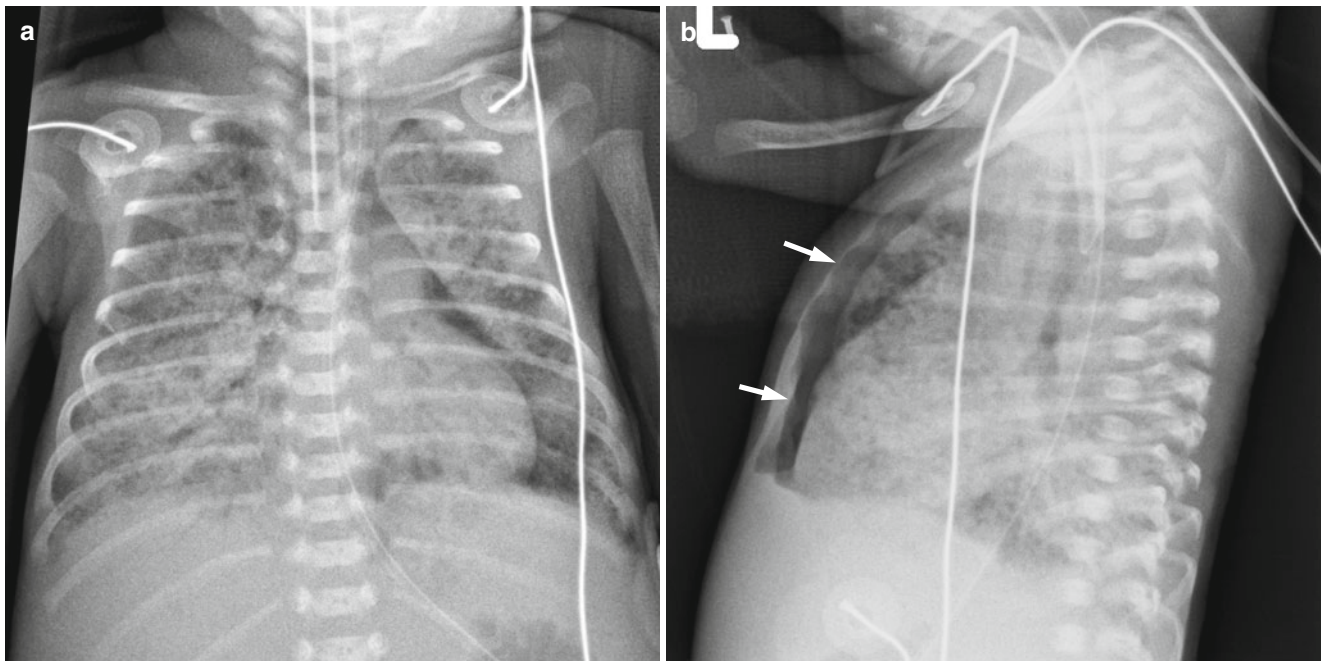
Pulmonary interstitial emphysema (PIE) and pneumothorax. (a) Frontal radiograph demonstrates bilateral diffuse PIE with left medial pneumothorax. (b) Cross-table lateral view of the same neonate
